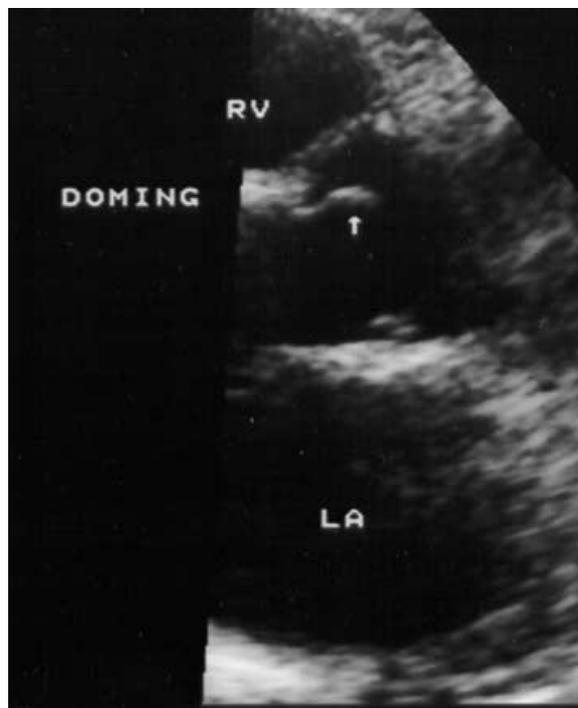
Systolic parasternal long-axis view of a patient with a BAV. Doming (arrow) is noted. Normally the leaflet should be parallel to the aortic wall when fully open during systole. LA = left atrium; RV = right ventricle.
